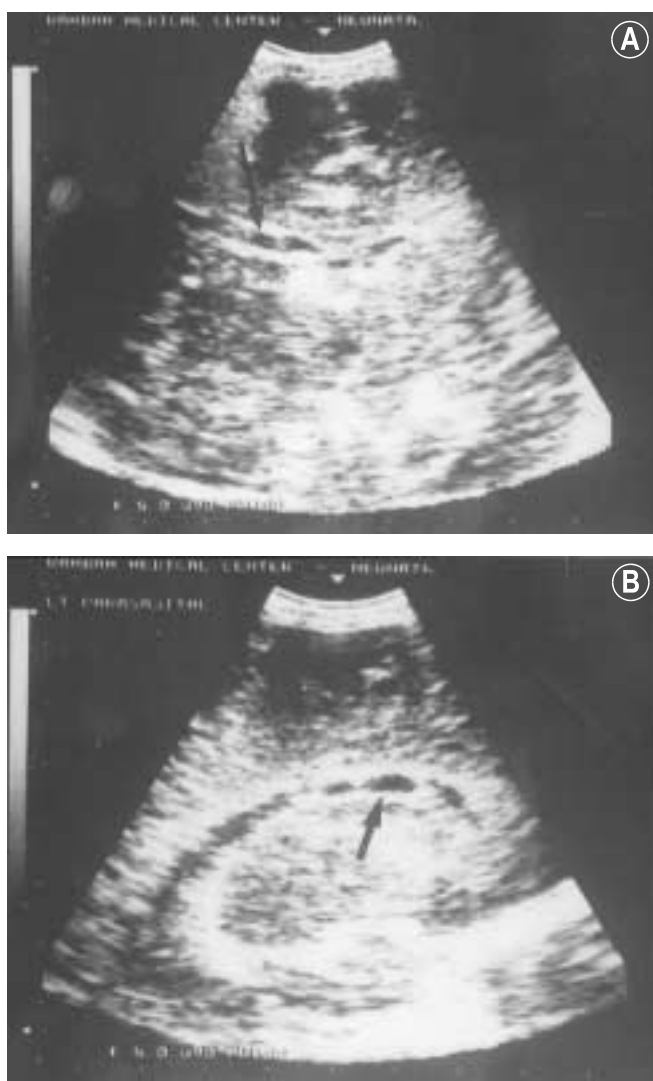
Ultrasound scan of brain at 12 hours of age. [A] coronal section showing a subependymal pseudocyst located anterolateral to the frontal horn of the lateral ventricle (arrow); [B] the same finding in a parasagittal section (arrow).
